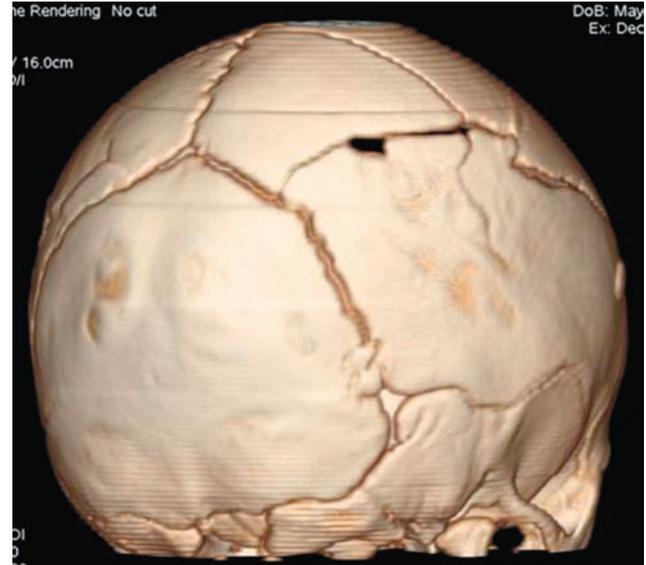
Three-dimensional computed tomographic scan of a child with skull fractures after a reported fall in a bathtub. Note multiple complex fractures. The father later confessed to abuse.
